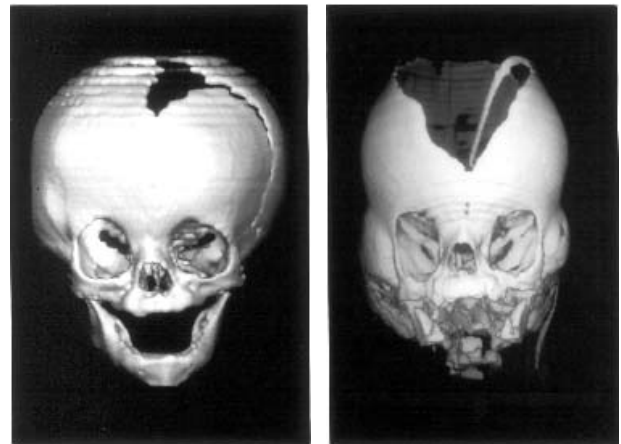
Three-dimensional CT scans in craniosynostosis syndromes. Plagiocephaly with facial asymmetry in a newborn with Muenke syndrome due to right unicoronal and metopic suture fusion (left). Severe synostosis of multiple sutures leading to cloverleaf skull and an extremely wide open fontanelle in a newborn with sporadic Pfeiffer syndrome and an *FGFR2* (Ser351Cys) mutation (right). (From Muenke and Wilkie [235]. Reprinted by permission of McGraw-Hill Companies Inc.)
